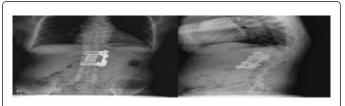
Plain AP A). and lateral B). radiographs were taken at 2 years after the operation. The T11 vertebra is in well healed state, although a slight reduction in height is observed. And the positions of the instruments and the spinal alignment are well maintained.
